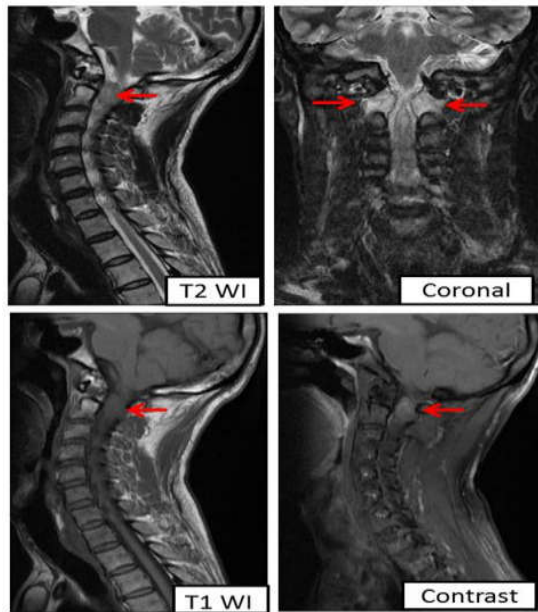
Magnetic Resonance Imaging (MRI) showing C1-C2 nerve sheath tumor.
